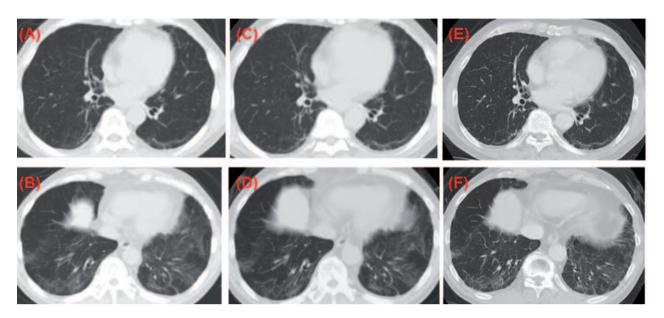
The findings of follow-up chest CT showed that the extent of ground-glass opacity on CT taken 15 months before admission (A, B) and 7 months after resection of colon cancer (E, F) was not significantly changed compared to CT taken on admission (C, D)
